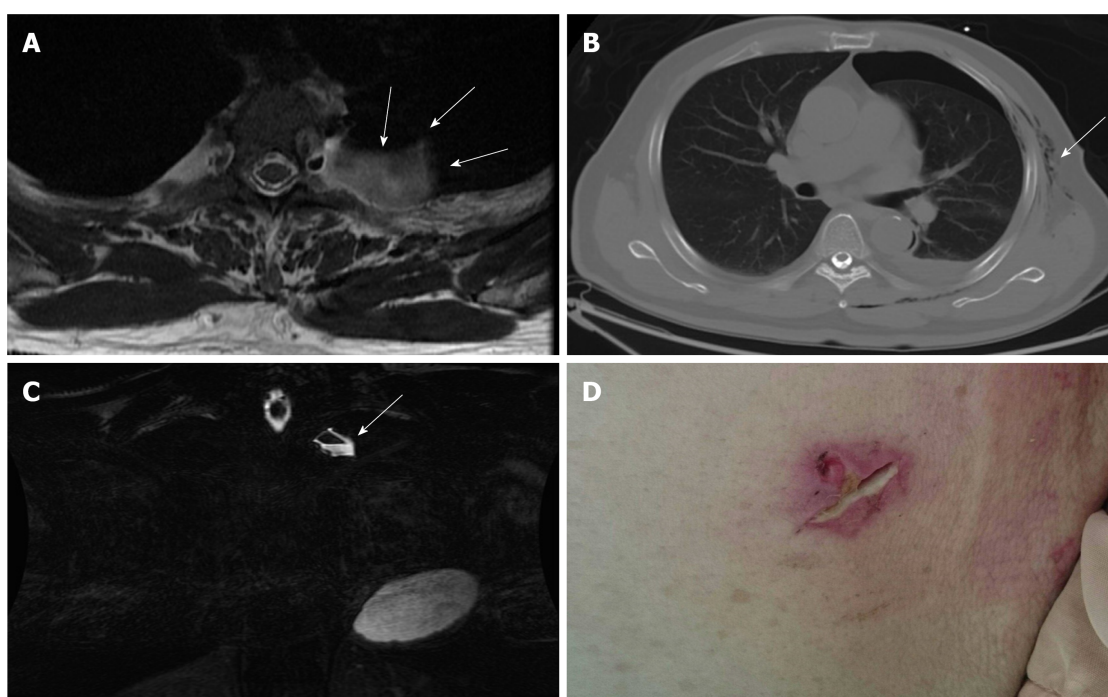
Pre-operative evaluations. A-B: T2-weighted magnetic resonance imaging in axial view (A) and fast spin echo, fat-suppression coronal view (B) showing a cystic pouch laterally surrounding the spinal nerve root at left T3 level (arrow), which may be derived from the neural foramen of the L3 level. The air-fluid level was also demonstrated (arrow); C) Axial view of chest computed tomography showing pneumothorax and subcutaneous emphysema (arrow); D) Poorly healing previous thoracoscopic access wound.
